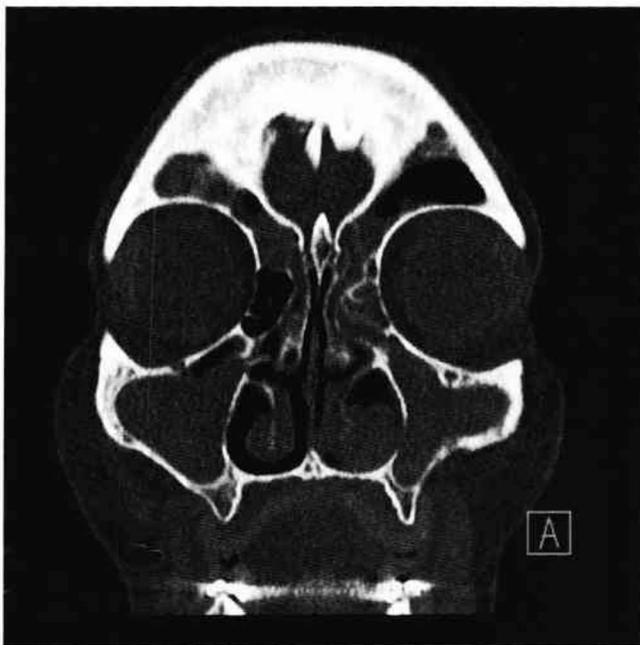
A sinus CT scan of a patient with chronic sinusitis demonstrates obstruction of outflow tracts leading from the frontal sinus and the maxillary sinus in addition to opacification of the ethmoid sinuses within the concha bullosa. This patient also has a polypoid mass in the left nasal cavity underneath the inferior turbinate.
